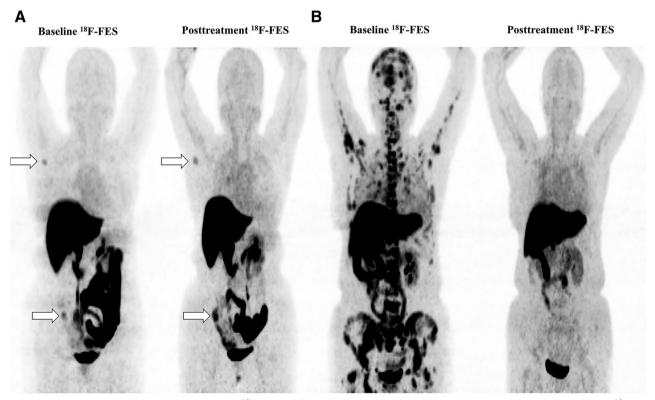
Representatives images of changes in ¹⁸F-FES uptake in the tumor during treatment. (A): Incomplete reduction of ¹⁸F-FES uptake. A 50-year-old premenopausal woman with invasive ductal breast cancer, who presented with bone and lymph node metastases after 42 months of adjuvant endocrine therapy (goserelin plus aromatase inhibitor). The patient received fulvestrant therapy as first-line endocrine therapy and had a median change in maximum standard uptake value (Δ SUVmax) of -5.1% and a progression-free survival (PFS) of 1.8 months. This patient is shown by the first bar in Figure 3. (B): Extensive reduction of ¹⁸F-FES uptake. A 51-year-old postmenopausal woman with invasive ductal breast cancer, who presented with lung and bone metastases after a 7-year disease-free interval (completed 5 years of adjuvant tamoxifen therapy). The patient received fulvestrant therapy as first-line endocrine therapy and had a median Δ SUVmax of 73.2% and a PFS of 11.7+ months. The patient's best response was stable disease. This patient is shown by the 29th bar in Figure 3.
